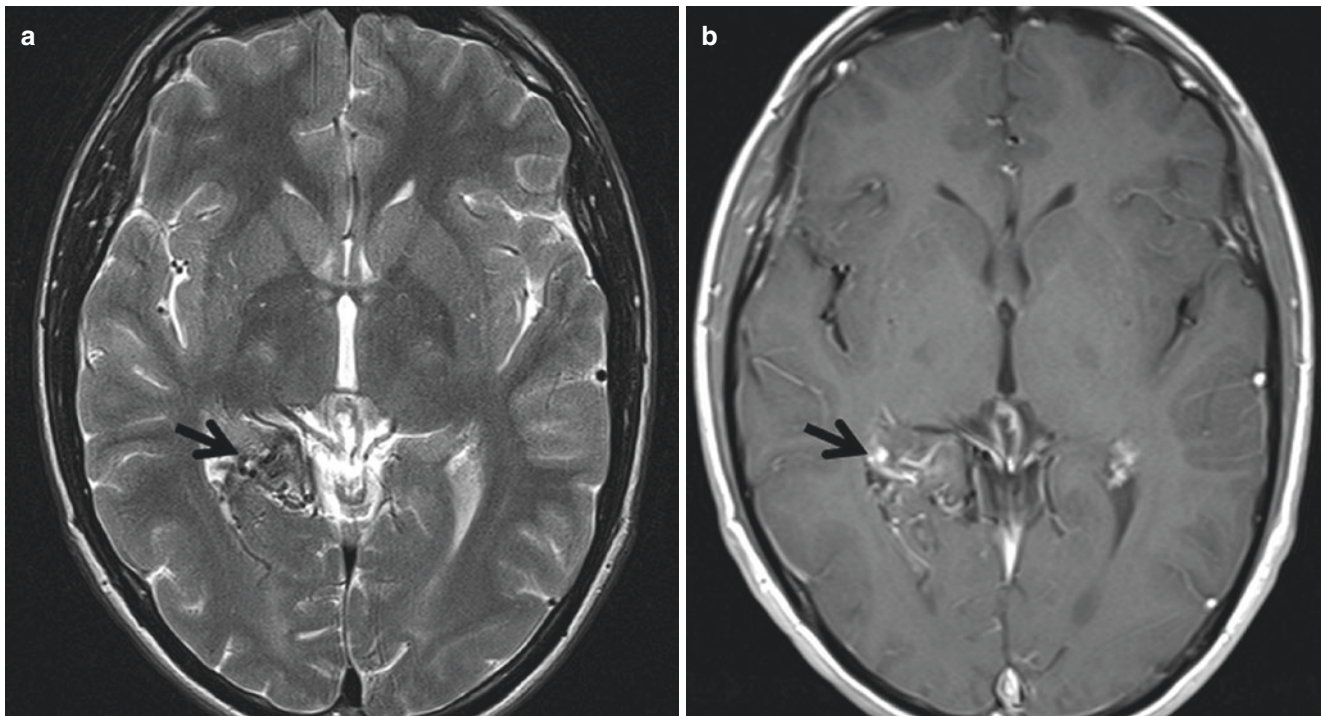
MRI of AVM. Patient presents with seizure. (a) Axial T2 MRI image demonstrates a cluster of abnormal flow void (*arrow*) in the right hippocampal tail, which shows serpiginous enhancement on the postcontrast T1 image (b)
